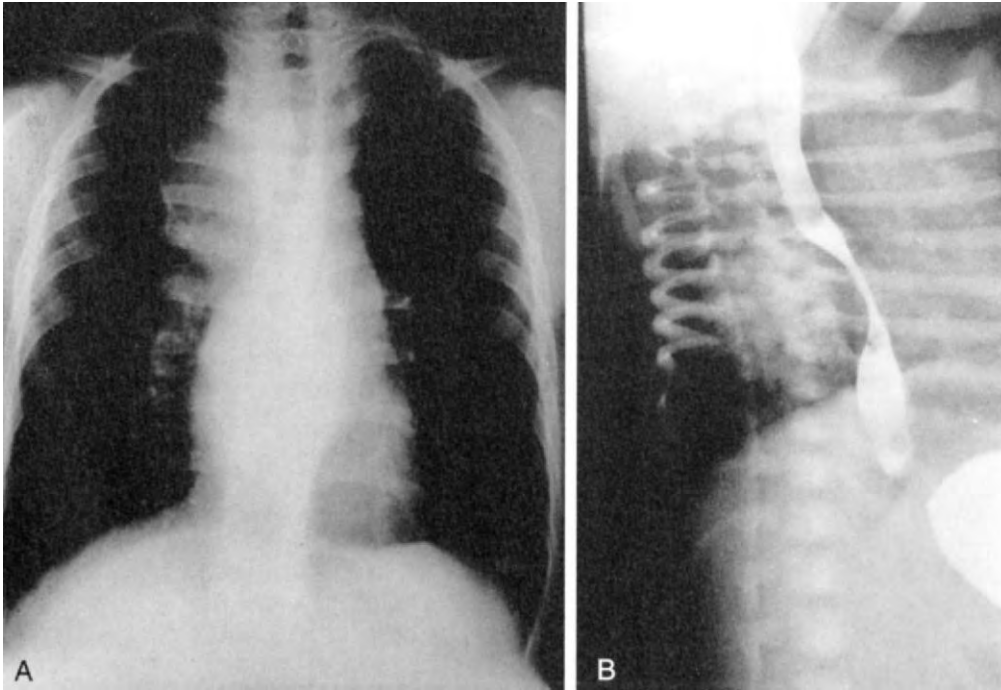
A child with vague respiratory symptoms or solid food dysphagia is found to have a mediastinal mass on a plain chest radiograph (A). The esophagus is deformed by the mass as seen on the contrast study (B). (From Ashcraft KW, Murphy JP, Sharp RJ, et al [eds]: *Pediatric Surgery*, 3rd ed. Philadelphia, WB Saunders, 2000, p 320.)
